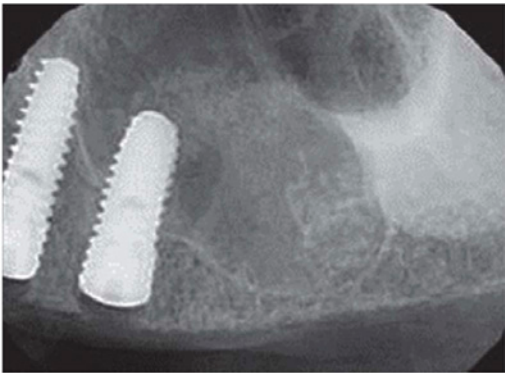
Radiograph immediately after sinus augmentation demonstrating the new osseous height achieved with sinus elevation and grafting
